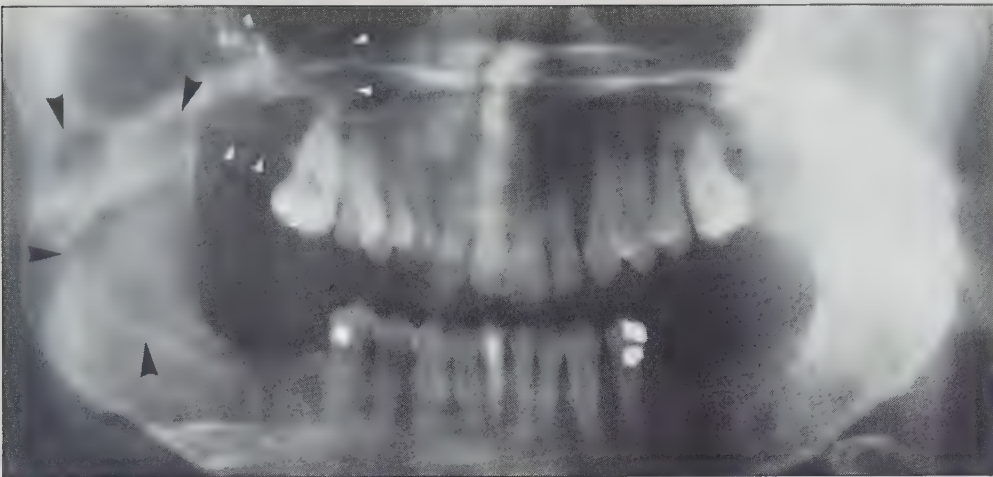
(Case 2): A 33-year-old male with basal cell nevus syndrome presented with an extensive recurrence 10 years postoperatively. Panoramic radiograph revealing a large multilocular radiolucency of the right mandibular ramus and angle (black arrows). Note that the condylar head does not appear to be involved. Also note the unilocular lesion in the right maxillary tuberosity (white arrows).
